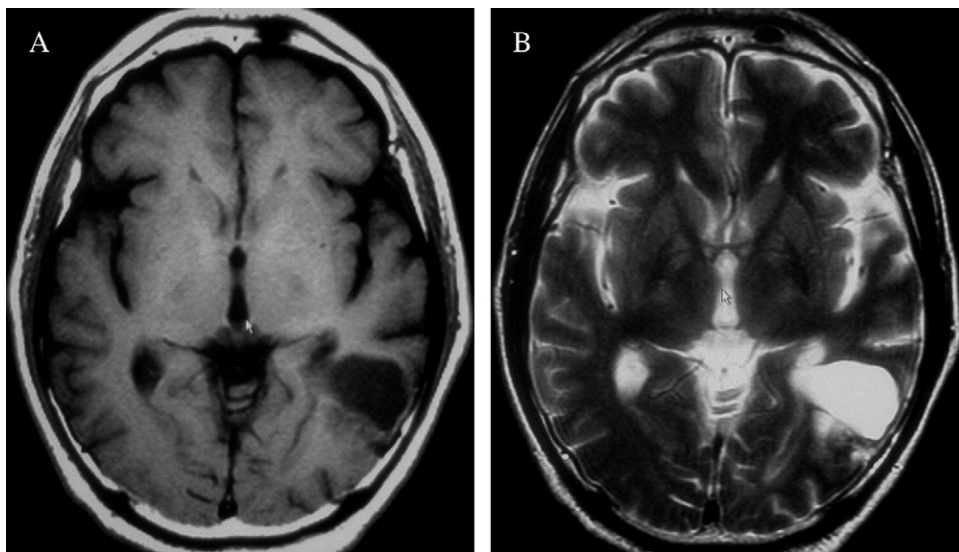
T₁-weighted (A) and T₂-weighted (B) MRI of the cystic lesion 10 years after radiosurgery of left temporal AVM (case 11). The patient is treated conservatively by analgetics and followed by serial neuroimaging.
